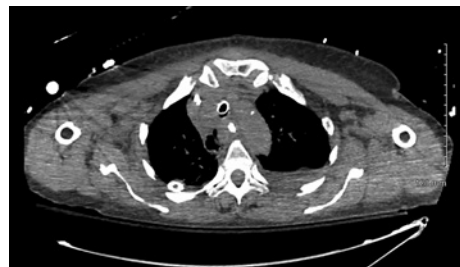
CT scan of thorax (axial) with pneumomediastinum.
